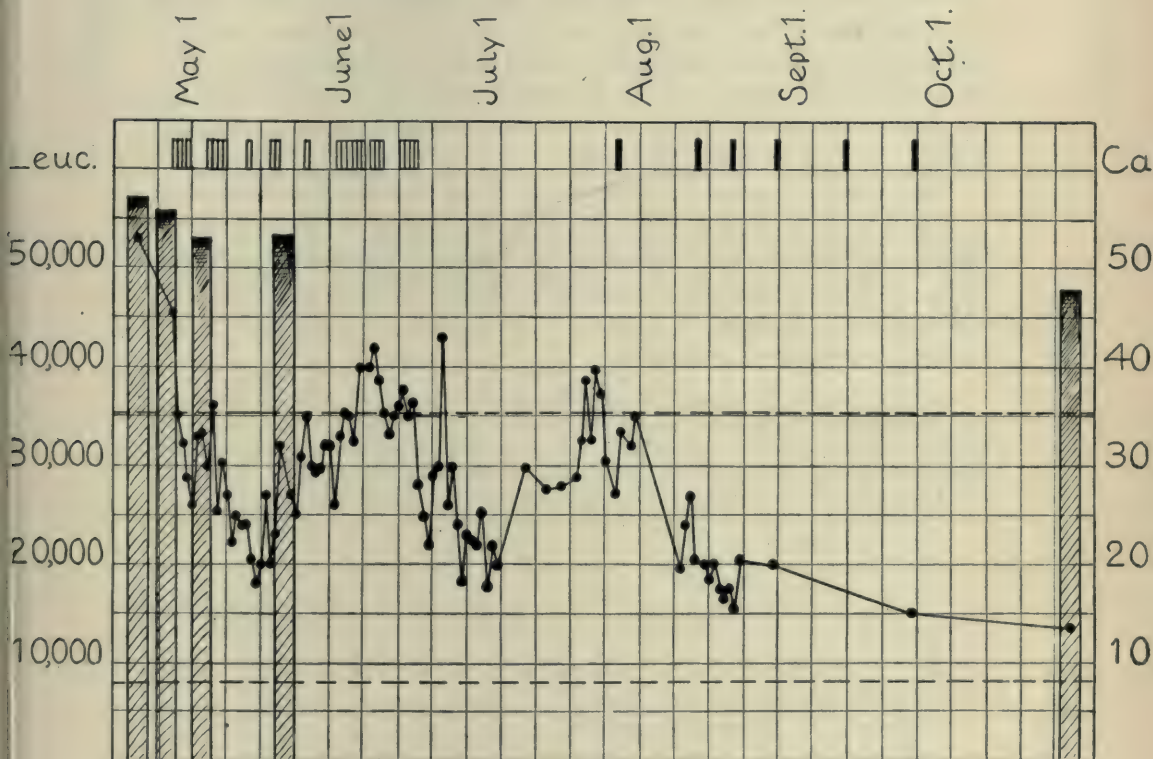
Chart showing the basal metabolism, shaded columns, and the leukocyte count, black dots and lines. The hollow rectangles at the top indicate Roentgen treatments, and the black ones radium treatments. The perpendicular rulings indicate periods of one week. The upper broken line represents the average basal metabolism for men from 50 to 60 years of age; the lower, the normal leukocyte count.
